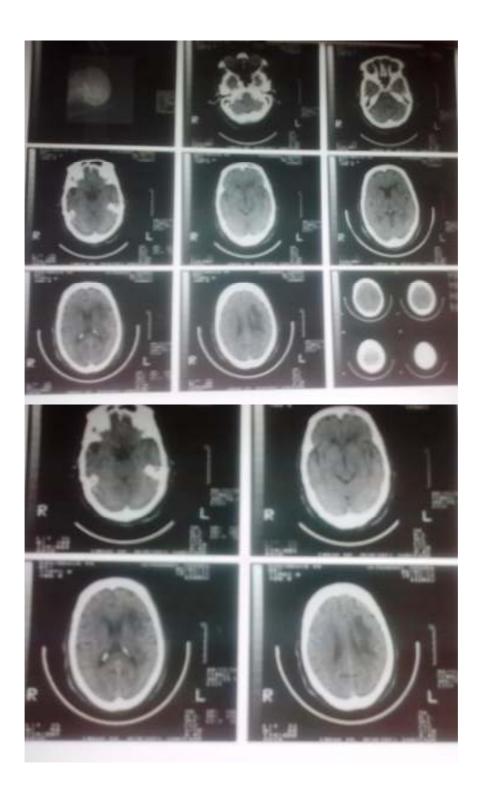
CT scan of case 1 (S.S.A.). Lesion can be seen in the left basal ganglia.
